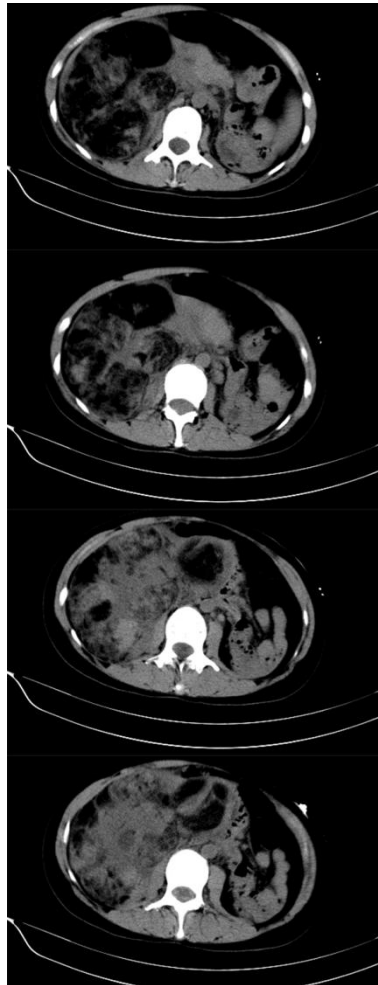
Computed tomography scans. Huge mixed density tumor in right abdominal and pelvic cavity. The surrounding tissue was squeezed.
